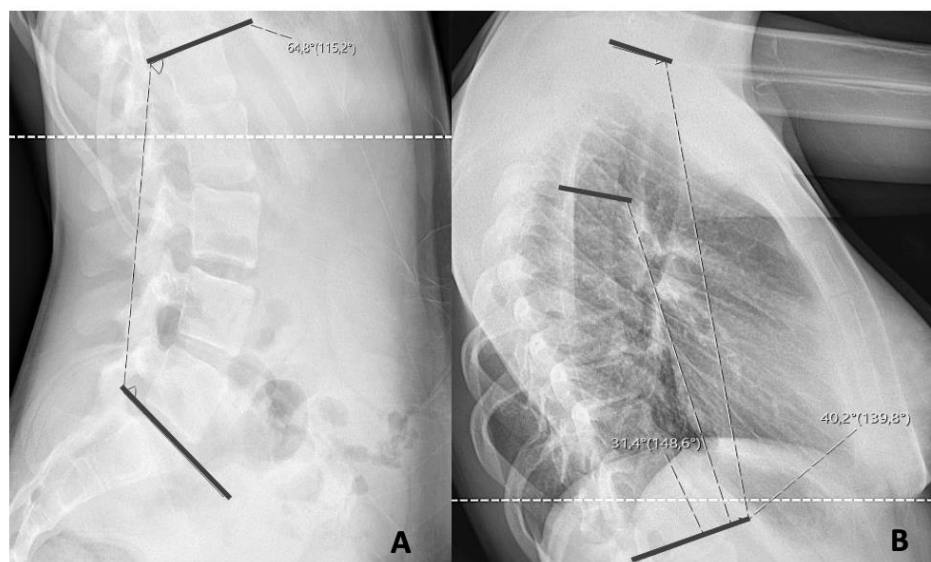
Measurement of parameters from the sagittal profile. A – Measurement of the lumbar lordosis between L1 an S1 in a lateral lumbar spine radiography. B - Measurement of the thoracic kyphosis between Th 1 an Th 12 as well as between Th 5 and Th 12 in a lateral thoracic spine radiography.
